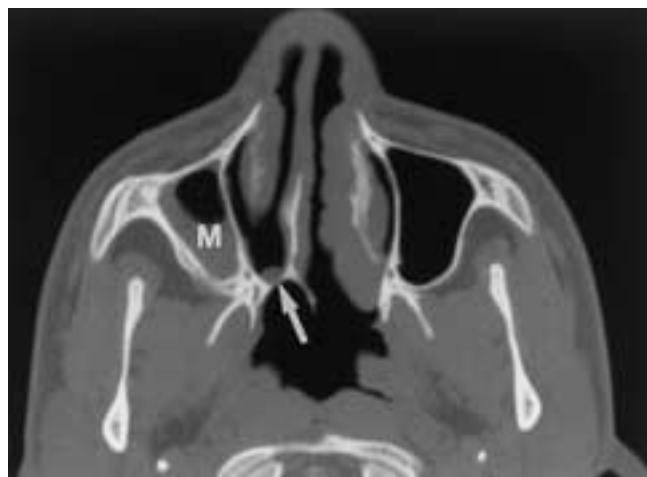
Unilateral choanal atresia in a 15-year-old boy. Axial CT demonstrates bony atresia of the right posterior choana. A thin wafer of bone (arrow) closes the space between the vomer and the posteromedial maxilla and pterygoid plates. There is hypoplasia of the right maxillary antrum (M), which contains mucoperiosteal thickening and secretions.
